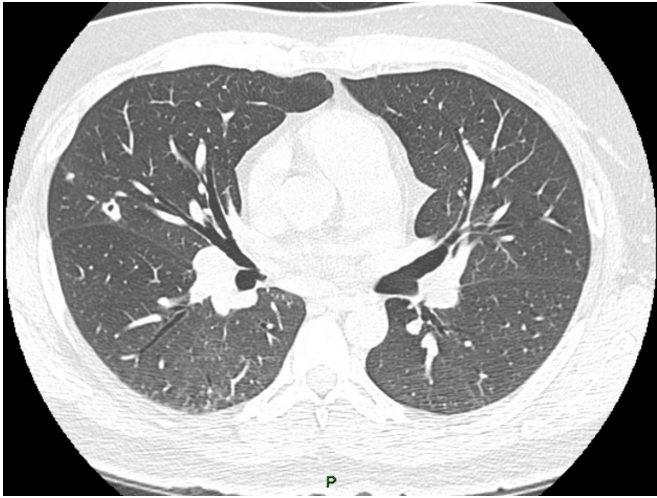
Chest CT scan on the 4th week of fluconazole treatment.
